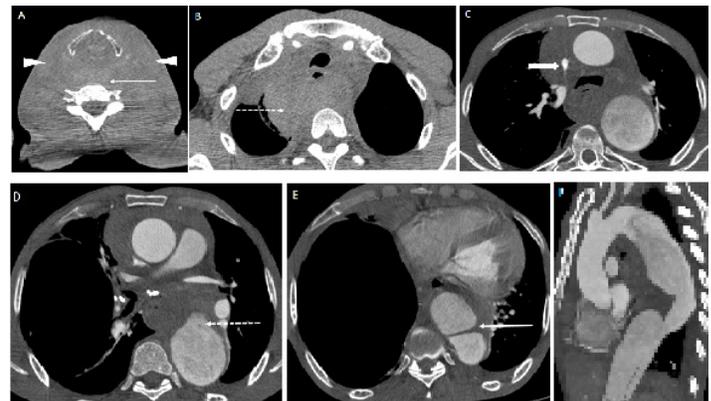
A and B: Non-enhanced computed tomography showing neck soft tissues swelling (arrowheads), retropharyngeal and mediastinal hematomas (arrow and dashed arrows, respectively)
